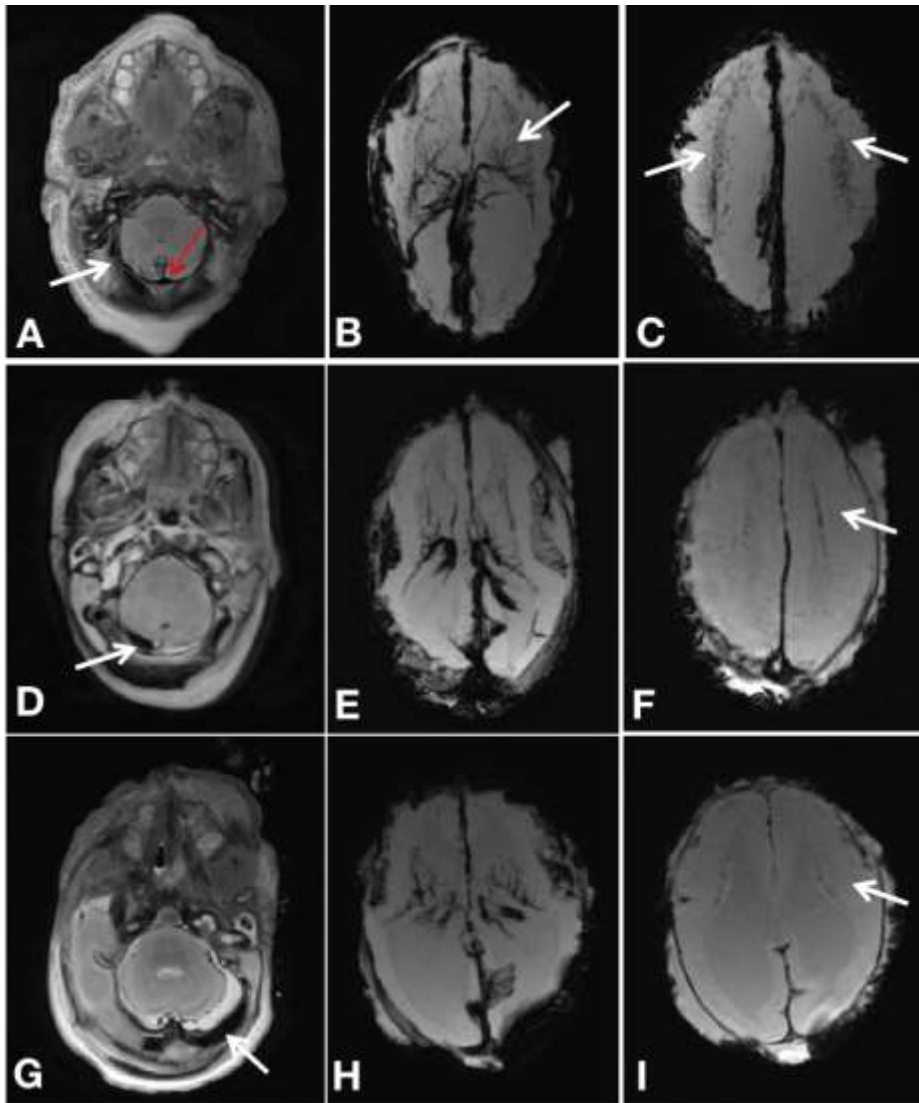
Postmortem MRI of three representative cases: Chiari II malformation with and without intracranial hemorrhage (ICH), and aqueduct stenosis with ICH.
